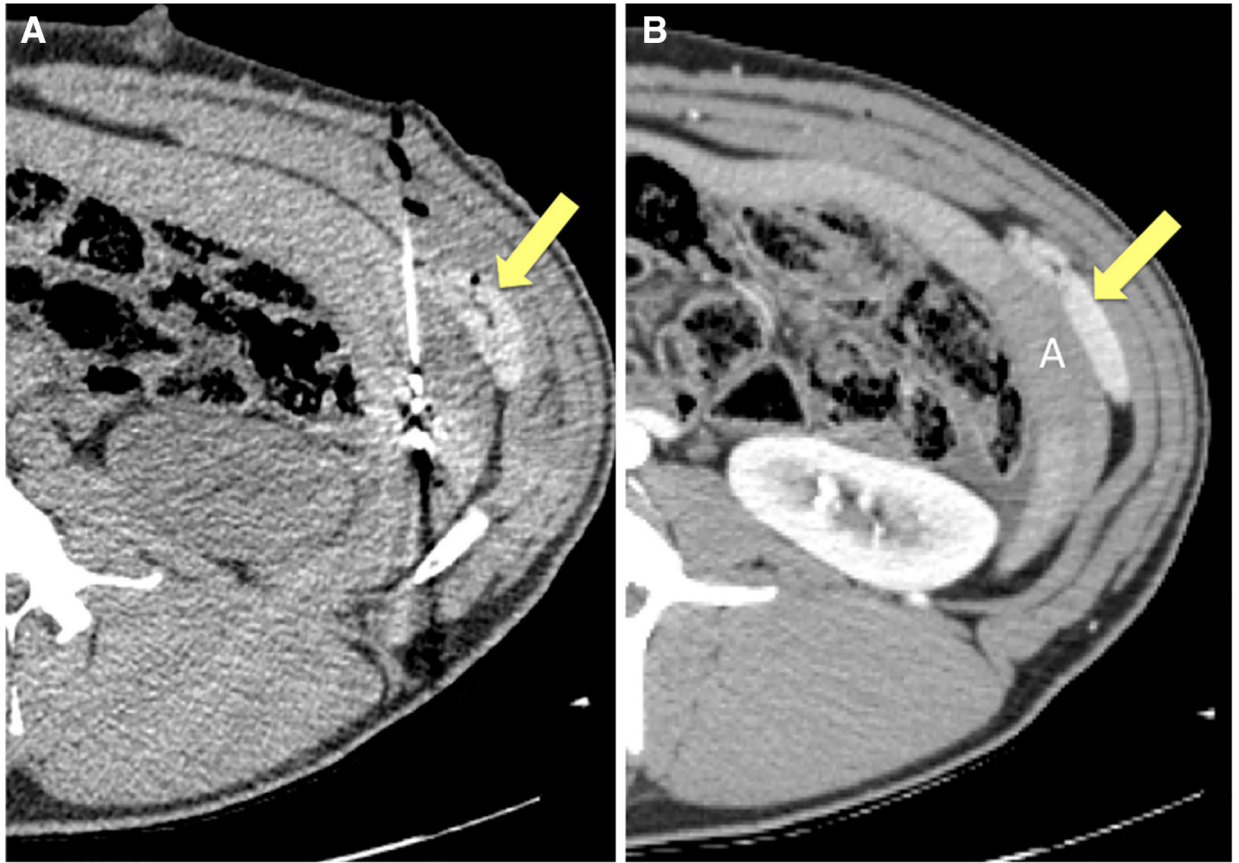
P407 gel position maintenance throughout MW ablation. P407 barrier (*arrow*) placement between MW antenna emission point within spleen and the body wall on non-contrast CT (A) and intravenous contrast-enhanced CT performed 2 h later (B) demonstrating completed ablation zone (*A*) and stable position of gel barrier (*arrow*)
